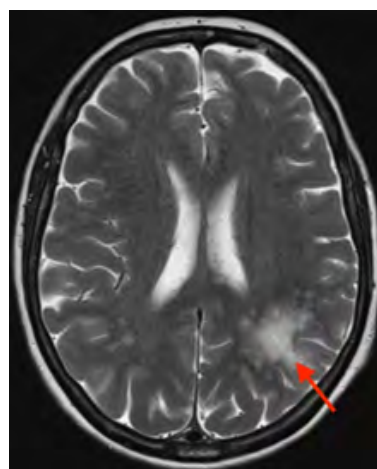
Axial contrast-enhanced T2-weighted MRI showing hyperintense signal areas on the left parietal lobe with small peripheral edema.
